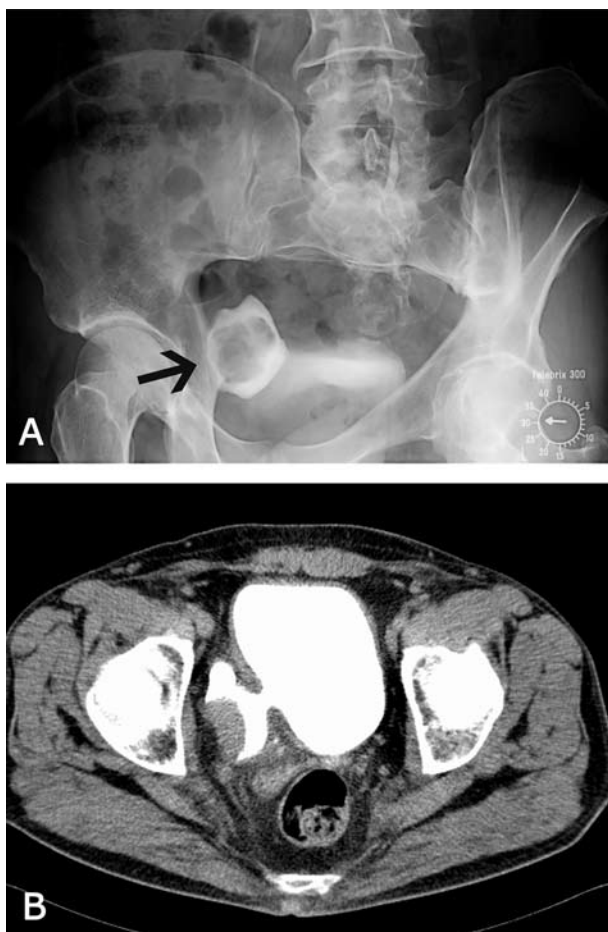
Radiographic findings: (A) intravenous urography showed bladder diverticulum on the right bladder wall measuring 5x6 cm with intraluminal filling defect; (B) abdominal computed tomography revealed a proliferative broad base tumor measuring 4x2 cm, which was related to the lateral wall of the narrow neck diverticula.
